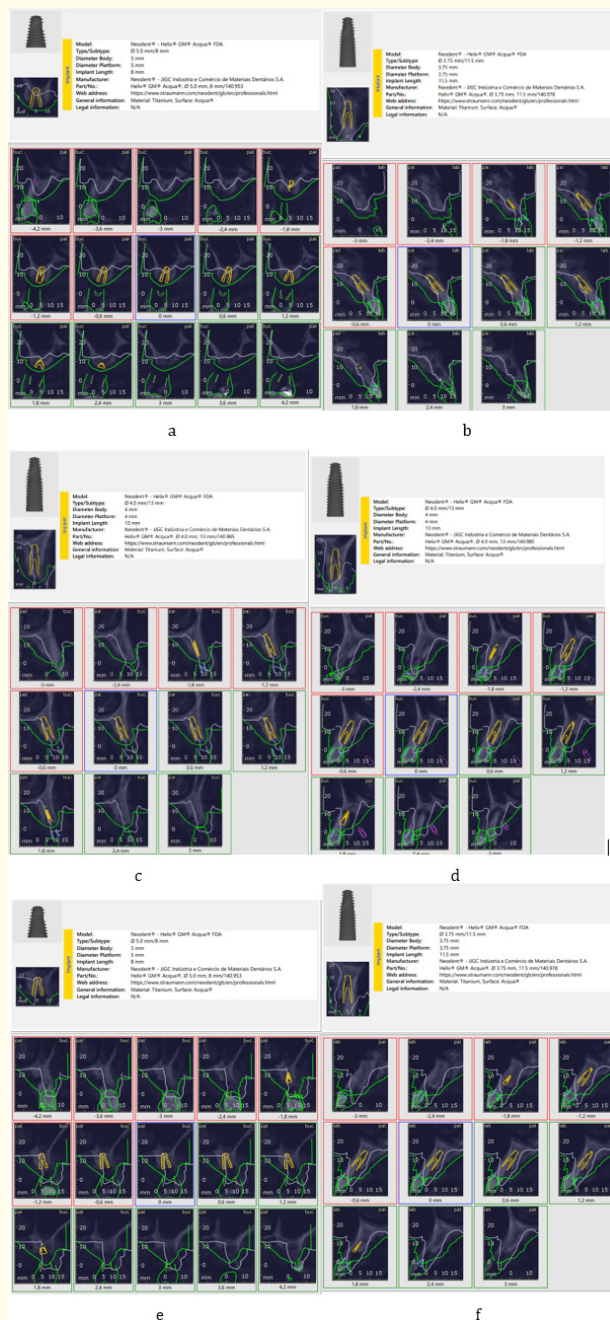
Cone Beam Cross-Sectional Slices with Virtual Implant Placement, Length, and Diameter. Selection: (a) Implant site 16 (b) Implant site 22 (c) Implant site 24 (d) Implant site 14 (e) Implant site 26 (f) Implant site 12.
